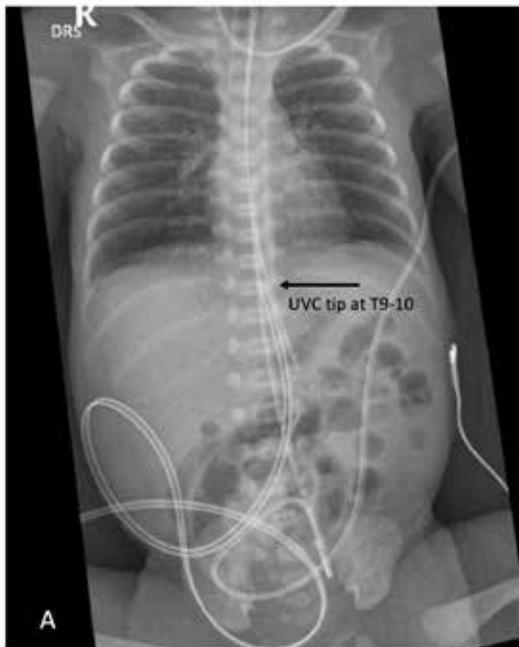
X-ray showing the tip of Umbilical Venous Catheter (UVC) at T9-10.
